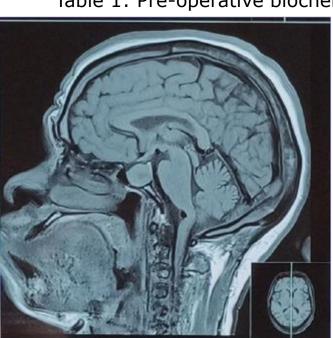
MRI scan showing pituitary enlargement (7*12 cm)
